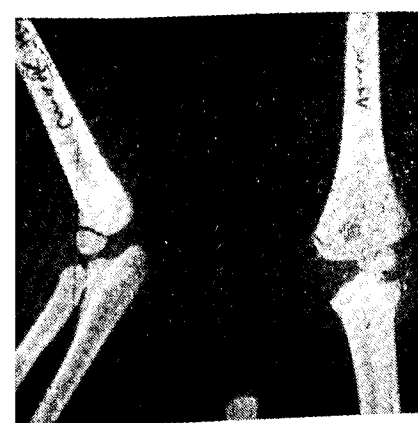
X-ray showing crack supra-condylar fracture.
